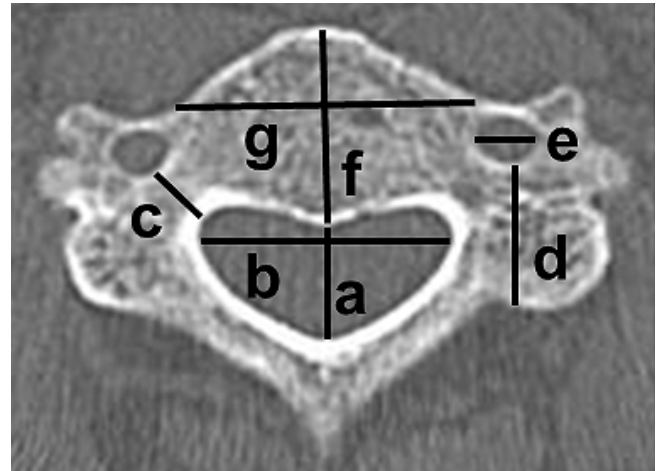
Axial reconstructed computed tomography image showing the following bony cervical spine parameters: (a) sagittal spinal canal diameter; (b) transverse spinal canal diameter; (c) pedicle width; (d) lateral mass thickness; (e) transverse foraminal diameter; (f) sagittal vertebral body diameter; and (g) transverse vertebral body diameter.
